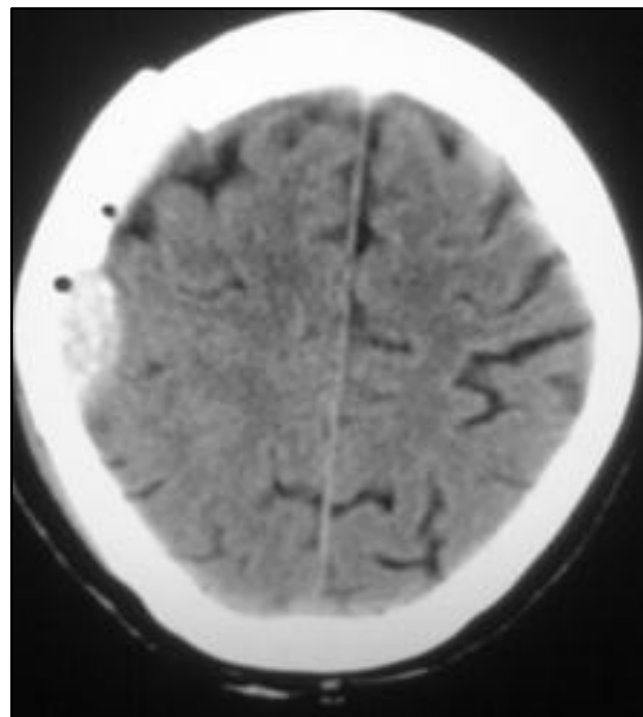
CT Axial Image showing EDH Underlying the Fracture with Air Pockets
